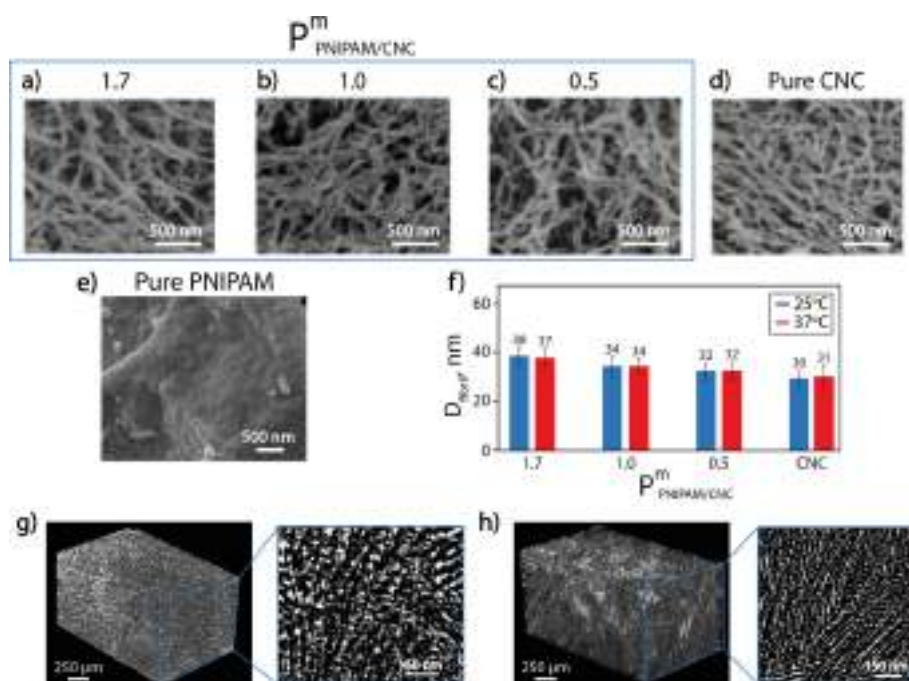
a)–c) SEM images of gels incubated at 25 °C with $c_{\text{tot}} = 9$ wt% and different ratios of PNIPAM and CNC: $P_{\text{PNIPAM/CNC}}^{\text{m}} = 1.7$ (a), $P_{\text{PNIPAM/CNC}}^{\text{m}} = 1.0$ (b) and $P_{\text{PNIPAM/CNC}}^{\text{m}} = 0.5$ (c); d) SEM image of gel obtained by salt-induced gelation of CNC; e) SEM image of a dried PNIPAM; f) average diameter of the fibrils for different ratios of $P_{\text{PNIPAM/CNC}}^{\text{m}}$ calculated based on SEM images; g–h) images of the structure of gel with $c_{\text{tot}} = 13$ wt% and a mass ratio $P_{\text{PNIPAM/CNC}}^{\text{m}} = 1.0$ obtained by X-ray microtomography at 25 °C (g) and 37 °C (h).
